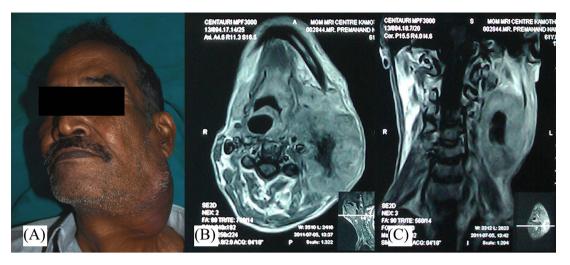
(A) Preoperative photograph of the patient showing a swelling in the neck (left side). (B and C) Preoperative magnetic resonance imaging scan showing heterointense mass with central nonenhanced necrotic area.
